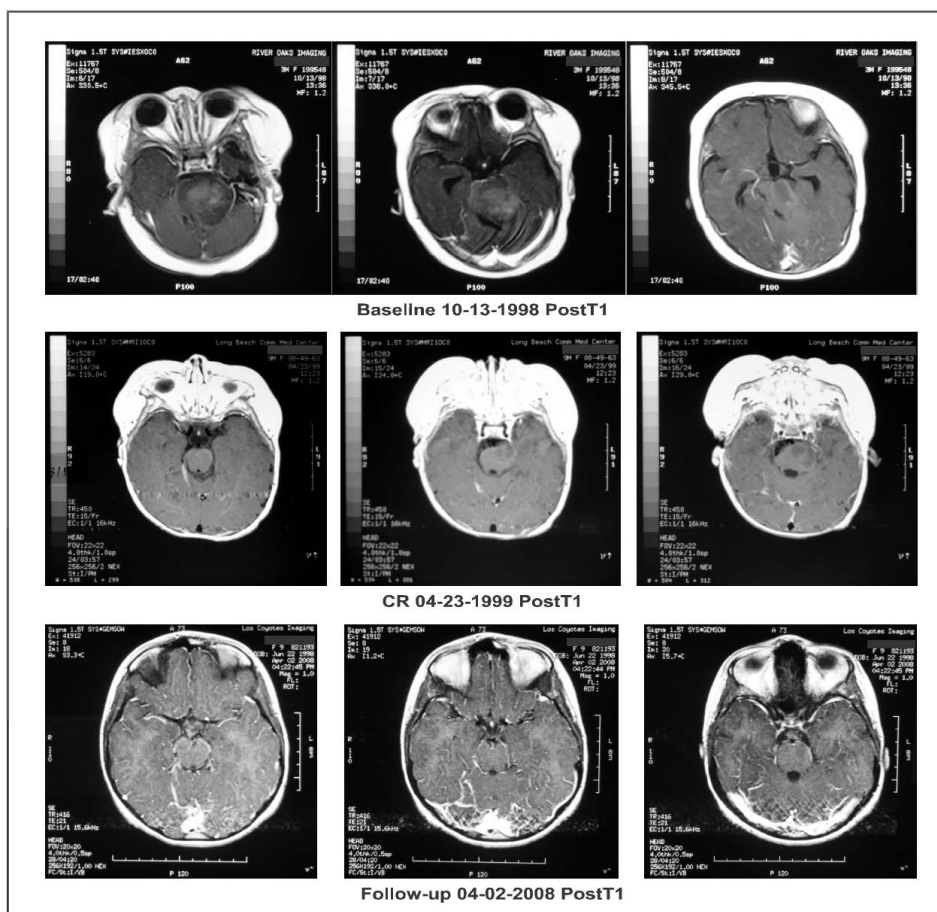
Axial brain magnetic resonance imaging (MRI) weighed in T2: “Baseline” demonstrates a high intensity contrast enhancing mass. “CR” shows a complete response (CR) of the high signal intensity mass following treatment. “Follow-up” shows persistence of the CR.
